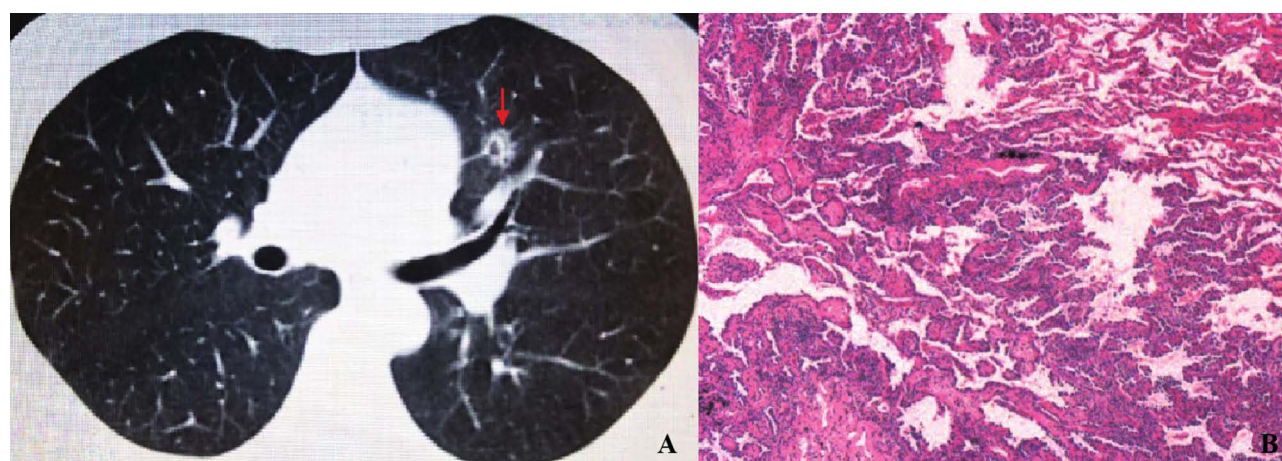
Lung CT of Metastatic Nodules. (A) Lung CT displaying multiple small nodules in both lungs, with enlargement in the lingual segment of the upper left lobe. The red arrow indicates the primary metastatic nodule in the upper lobe of the left lung, which was found to be slightly enlarged compared to previous imaging, suggesting disease progression. (B) Pathological section showing cancer cell invasion in lung tissue. This figure relates to the nursing care plan by highlighting the patient's respiratory health needs, a consideration during symptom management with DS8201 treatment.
